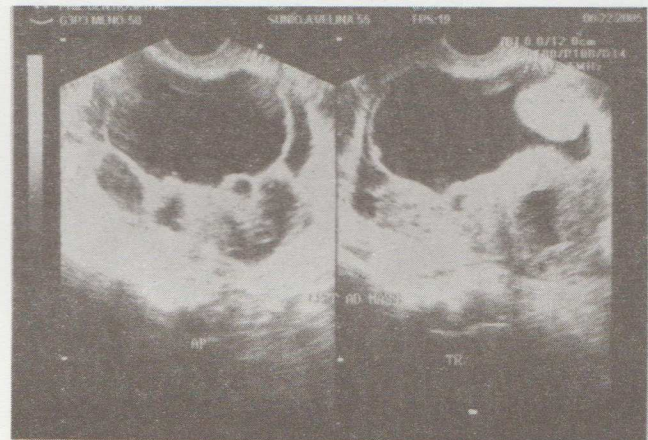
Sonographic picture of a multiloculated anechoic cystic pelvic mass anterosuperior to the uterus and more to its left, measuring 9.2 cm x 8.9 cm x 6.8 cm with several solid masses within, the largest of which measured 5.8 cm x 4.0 cm x 3.9 cm.
